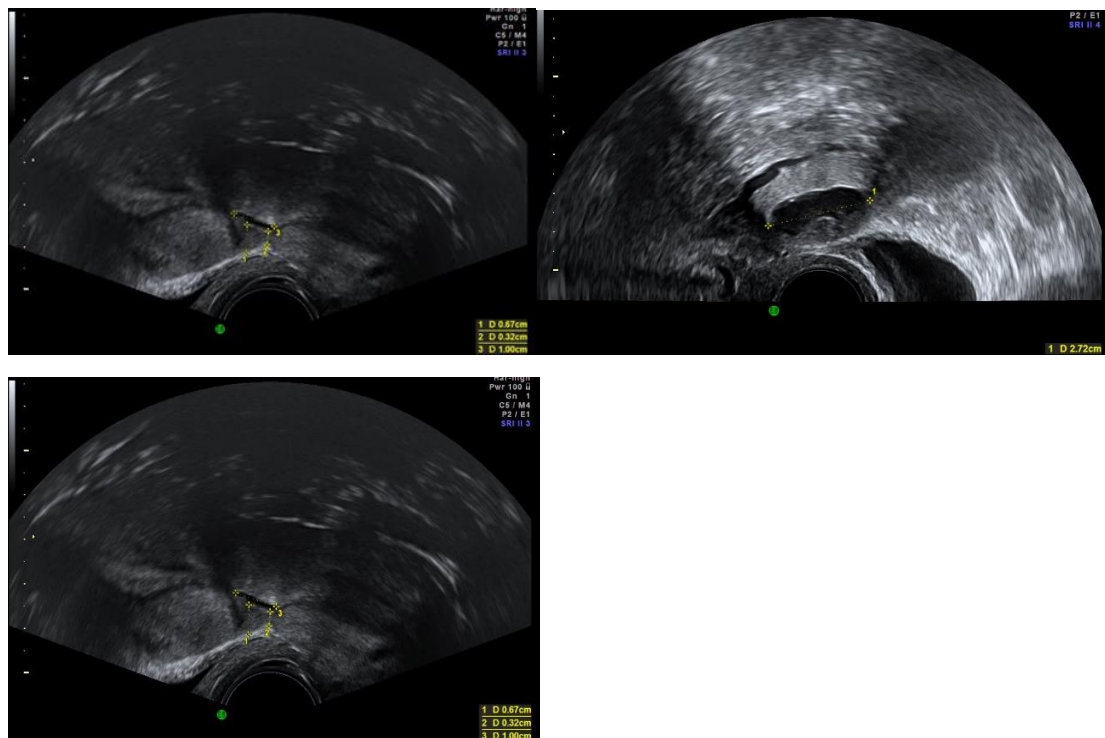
Ultrasound of isthmocele showing anechoic area in the anterior isthmic area; a) sagittal plane, b) transverse plane, c) after hysteroscopic isthmoplasty
